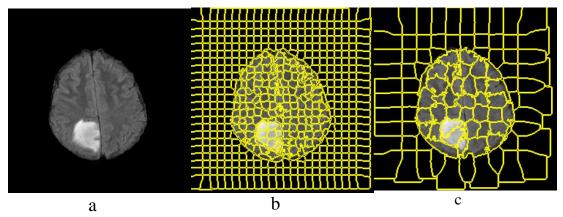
Superpixel segmentation for one slice of the MRI image with different window sizes: a) original MRI FLAIR image with a Grade II tumour, b) superpixel segmentation with S = 10 (initial grids 10×10) and m = 0.2, c) superpixel segmentation with S = 20 (initial grids 20×20) and m = 0.2.
